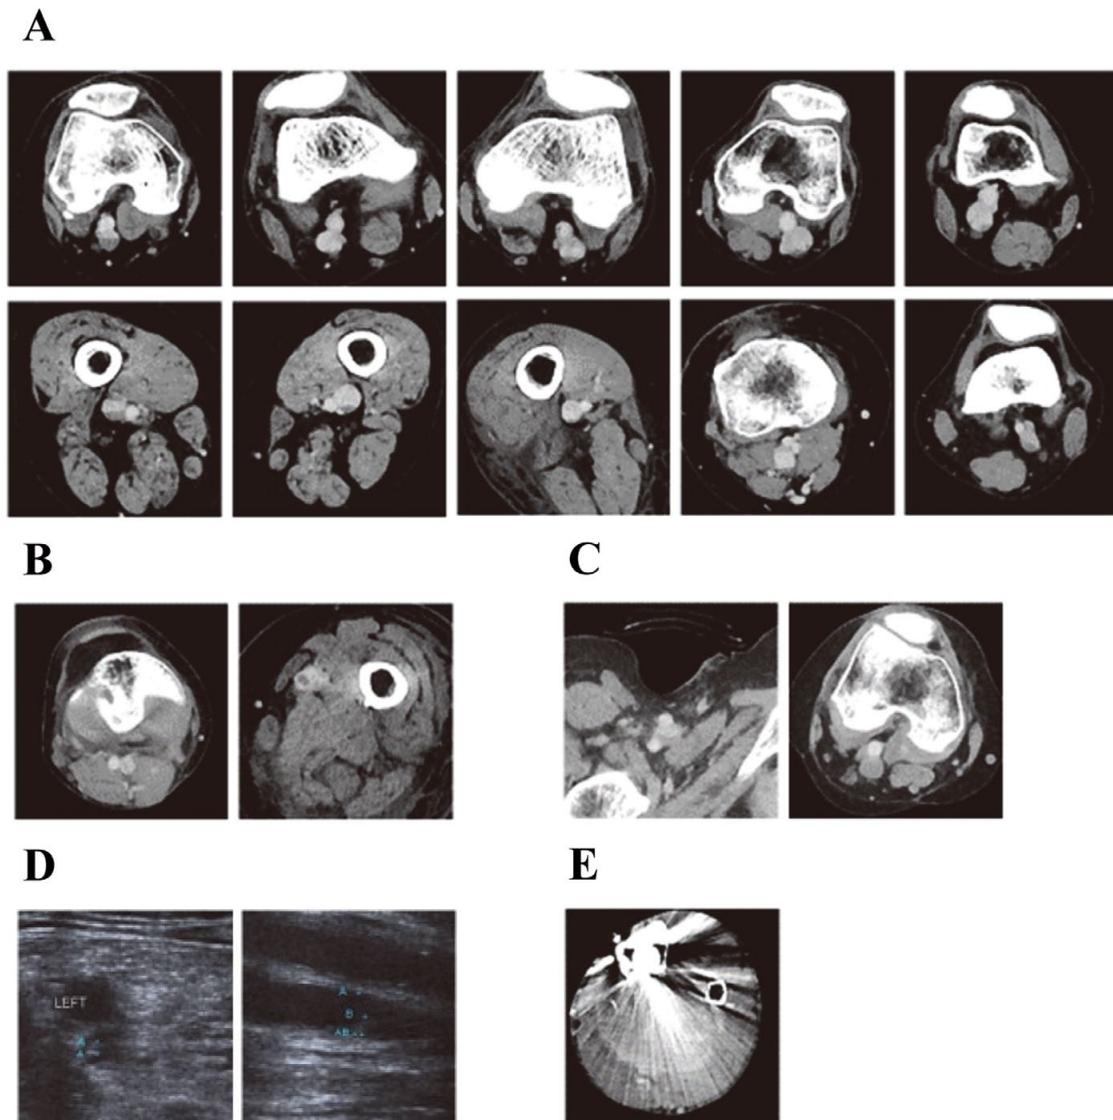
False-positive and false-negative images. (A) 10 false-positive segments with eccentric defects on CTV (above the knee). (B) 2 false-positive segments with concentric defects on CTV (above the knee). (C) 2 false-positive segments with poor contrast by postoperative vascular compression (above the knee in 1 patient). (D) 1 false-negative segment with eccentric DVT on US (above the knee). (E) 1 false-negative segment with poor image on CTV by metal artifact (below the knee). CTV, computed tomography venography; DVT, deep vein thrombosis; US, ultrasonography.
